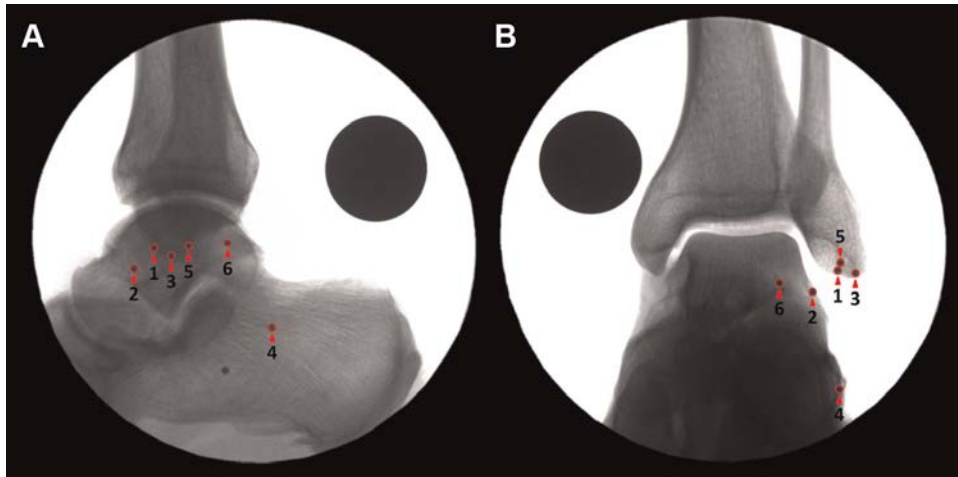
Radiograph of the ankle joint in (A) lateral and (B) mortise views: (1) ATFL proximal attachment; (2) ATFL distal attachment; (3) CFL proximal attachment; (4) CFL distal attachment; (5) PTFL proximal attachment; (6) PTFL distal attachment (Haytmanek et al., 2015).
